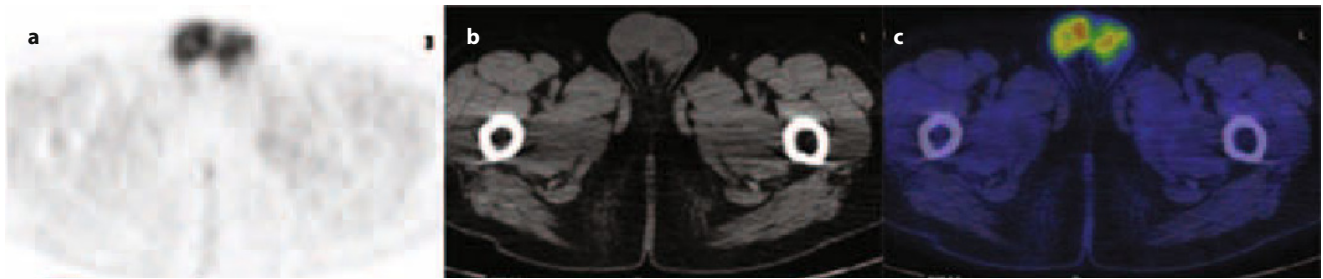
Transaxial ^{18}F FDG-PET/CT sections (PET in a, CT in b, fused PET/CT in c), showing symmetric and diffuse ^{18}F FDG uptake at both testicles in an adult patient
